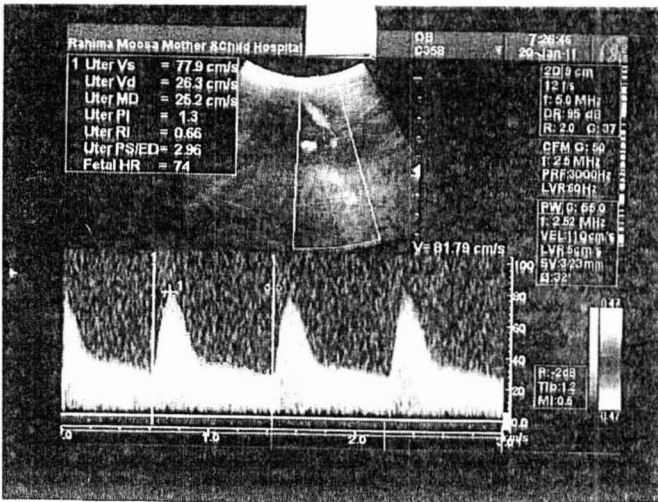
Demonstrating a normal second trimester uterine artery Doppler (Researchers collection)
